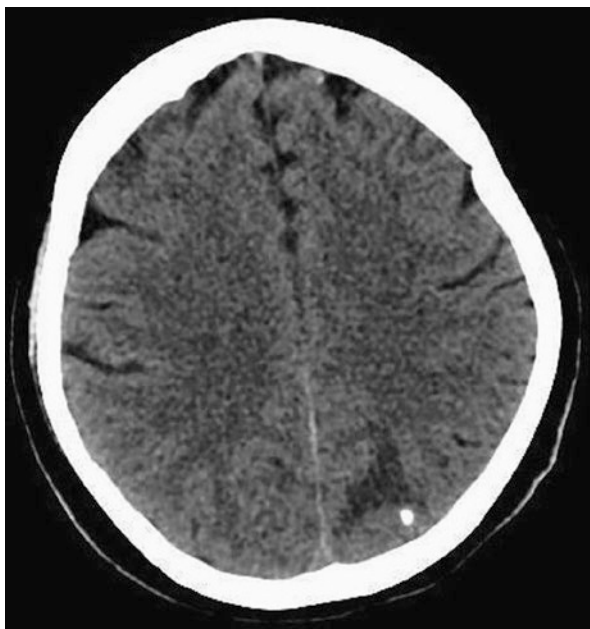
CT head showing an area of vasogenic edema within the left occipital lobe, with a calcified spot within the cortex adjacent to it. The differential diagnosis of this appearance is infection such as TB, cysticercosis, toxoplasma; cavernous hemangioma, and metastasis
